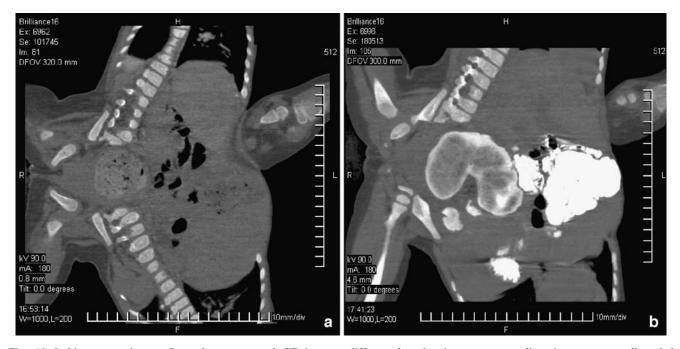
Ischiopagus twins. a Coronal reconstructed CT image shows three legs (tripus). The left leg here was rudimentary with each twin having one normal hip joint. b Similar orientation on a
